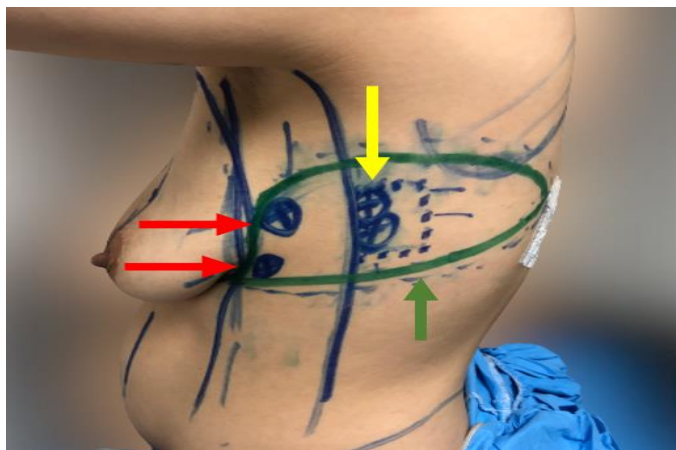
Preoperative TDAP flap markings. Yellow arrow pointing to two TDA perforators identified by doppler 8 and 9 cm below the posterior axillary fold and 1 cm behind the lateral border of the LD muscle. Red arrows pointing to lateral intercostal artery perforators. Green arrow pointing to the flap design
